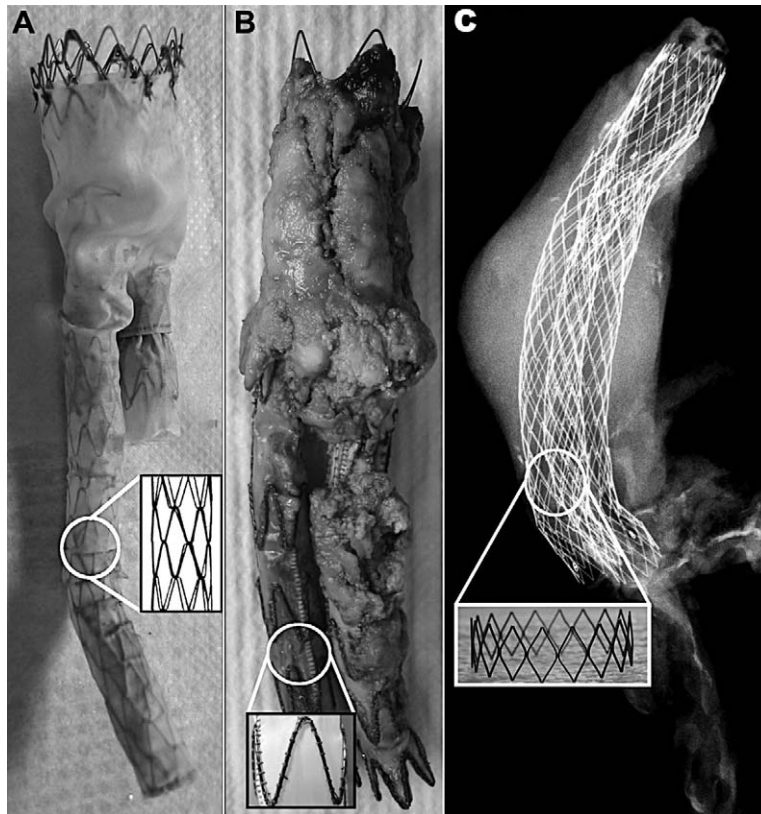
♦ The 3 types of explanted stent-grafts and their macroscopic structure. (A) Vanguard stent-grafts were made of zigzag nitinol struts attached by polypropylene sutures and covered by a woven polyester graft. A bare stent was present at the proximal end of the implant to ensure better aortic fixation. The graft was made from yarns of microfilaments ($\phi=10\ \mu\text{m}$), regularly interlaced in ends and picks to produce a continuous sheath. (B) Talent stent-grafts were made of a monofilament polyester fabric (Dacron LPS prepared with $40\text{-}\mu\text{m}$ -diameter filaments) fixed by polyester suture to NiTi spring wires ($\phi=500\ \mu\text{m}$). NiTi wires were connected to each other by a longitudinal connecting bar, thus increasing the kinking resistance of the implant. The NiTi structure was located inside the graft at the proximal end and outside the graft at the limb. A bare stent was present at the proximal neck. (C) Radiograph of an AneuRx stent-graft retrieved with a complete aneurysm. AneuRx endografts had no bare stent. The polyester graft, similar to that of Vanguard devices, was supported by a square-shaped nitinol exoskeleton ($\sim 300\times 300\ \mu\text{m}$).
